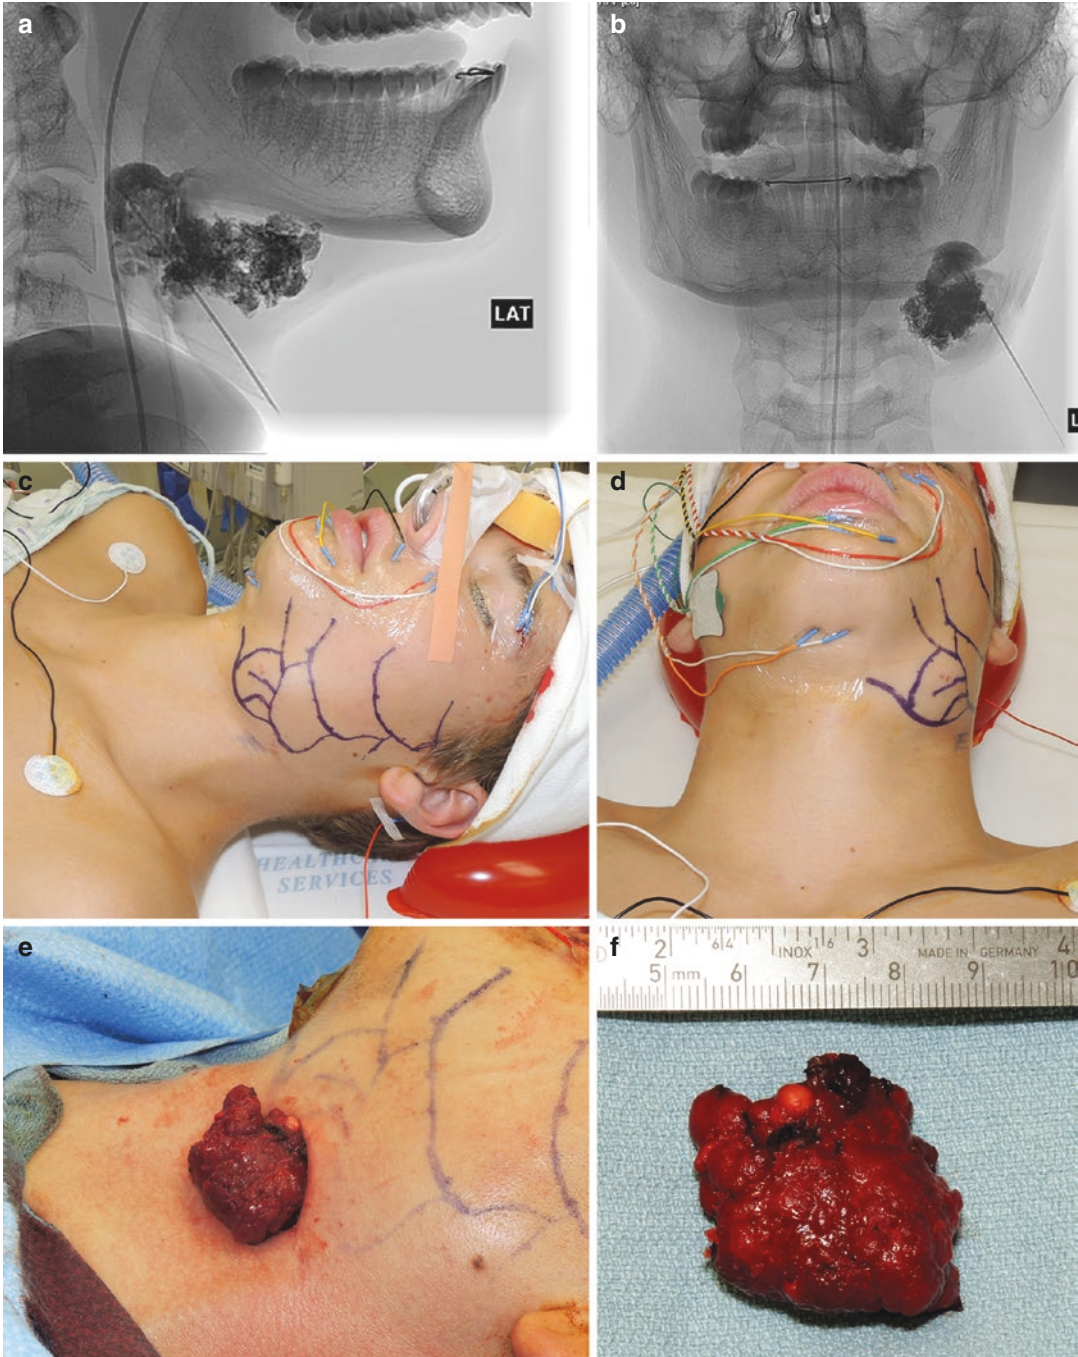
Frontal and lateral intraprocedural radiographic images following percutaneous lesion embolization with n-butyl cyanoacrylate (a, b), preoperative facial nerve
